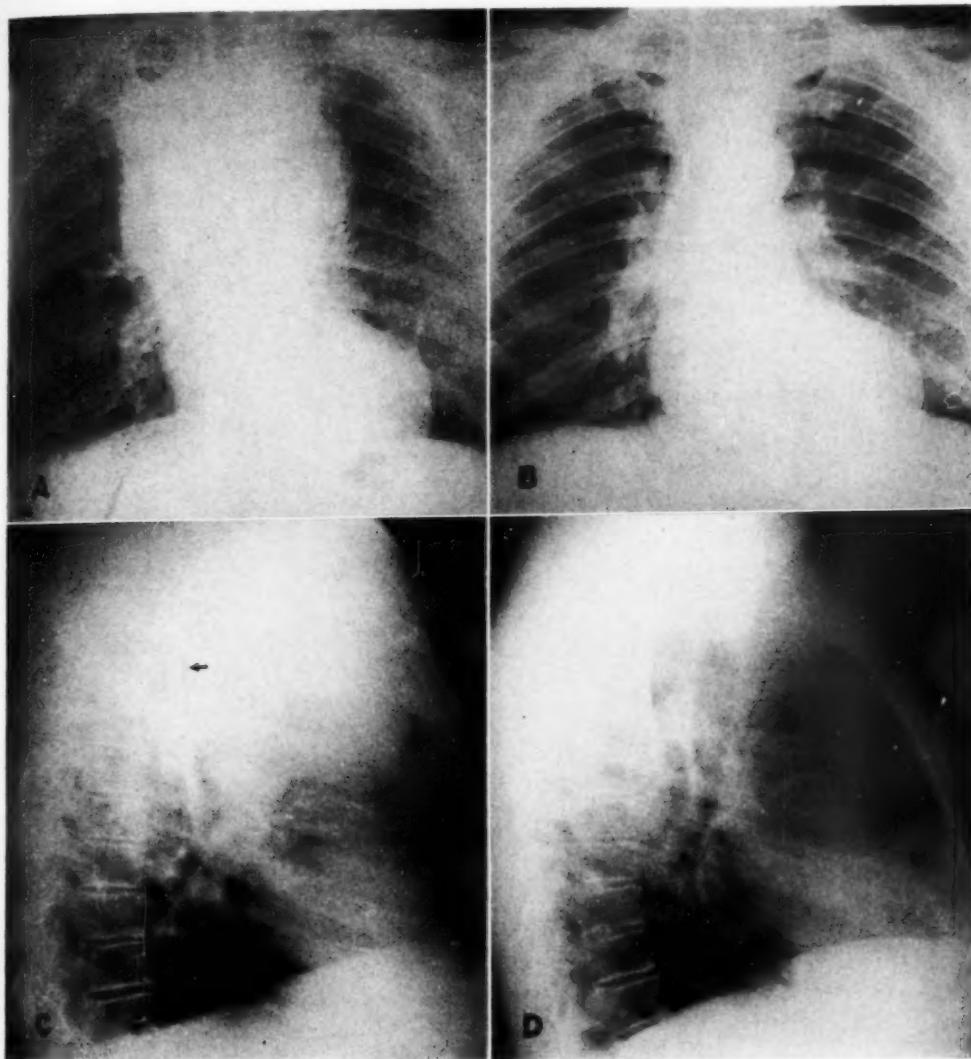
C. L., 57-year-old coal miner with brief history (one month) of dyspnea, orthopnea, swelling of head and neck, and extensive superficial collaterals visualized on the trunk. Anaplastic epidermoid carcinoma, right upper lobe bronchus. Patient received 3,500 r to the mediastinal tumor in fifty-one days. A remission of one year followed this single course of roentgen therapy.
